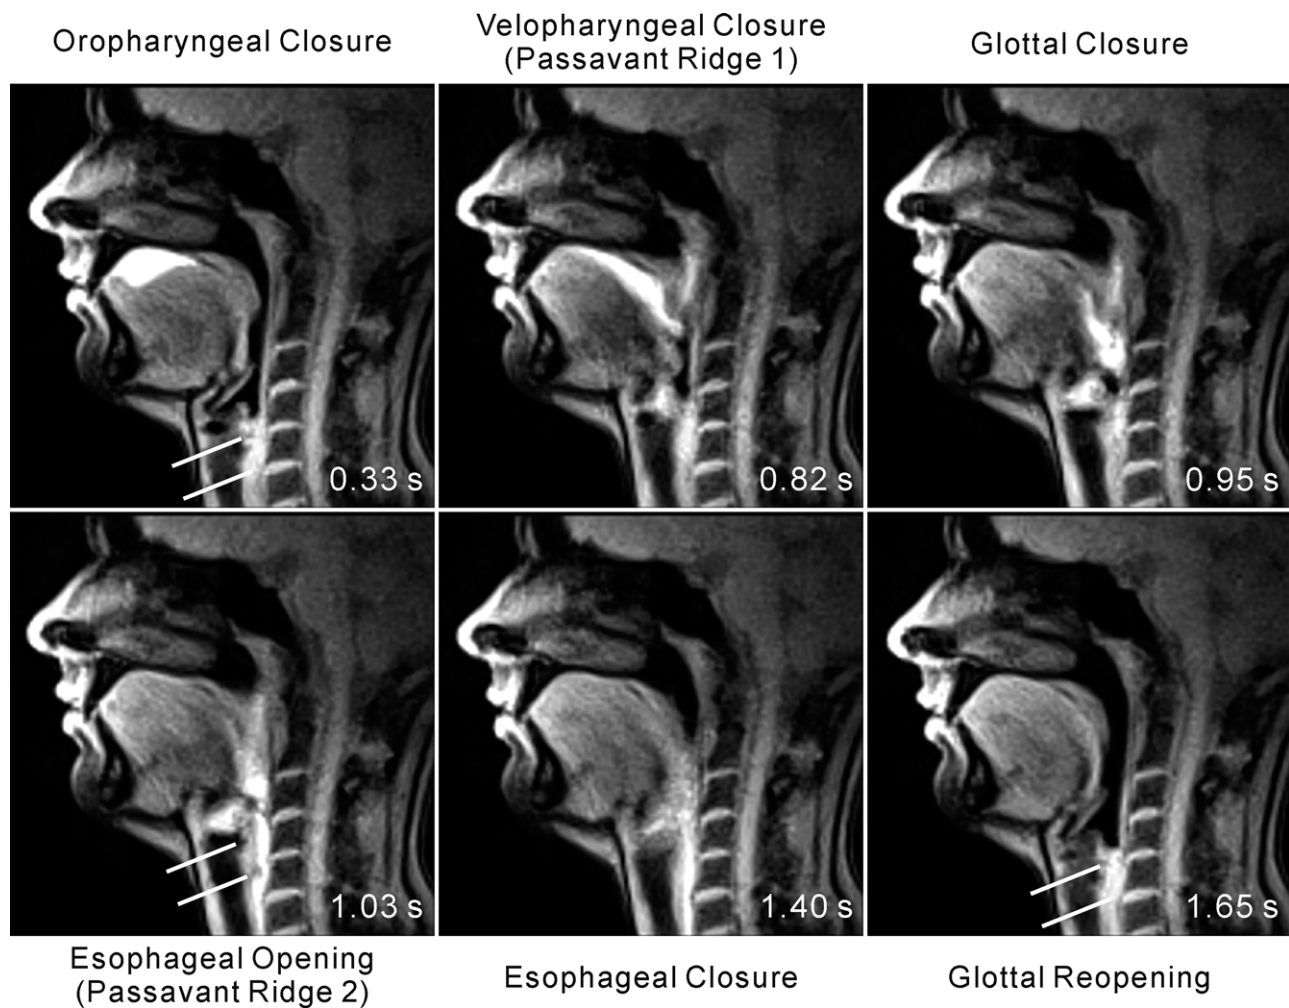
Real-time MRI of normal swallowing in the mid-sagittal plane (26-year-old healthy female subject). The images (TR/TE = 2.17/1.44 msec, flip angle 5°, field of view $192 \times 192 \text{ mm}^2$, $1.5 \times 1.5 \times 10 \text{ mm}^3$) with an acquisition time of 41.23 msec represent distinct swallowing events from a corresponding movie of a single swallow at 24.3 fps (see Supporting Movie 1). Numbers refer to relative timings with reference to the beginning of the esophageal opening (ie, 1.03 sec). The ascent and descent of the larynx is highlighted by double lines.
